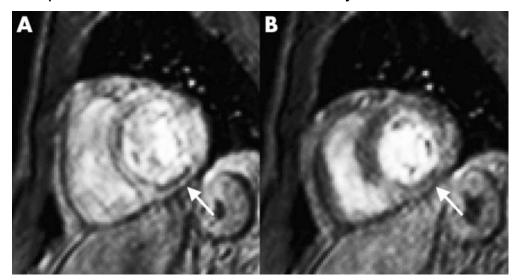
MRI imaging with pharmacological stress showing Magnetic resonance perfusion images during rest (panel A) and stress (panel B) showing a fixed perfusion defect in the inferior perfusion defect in the inferior wall (white arrows). ²⁴
